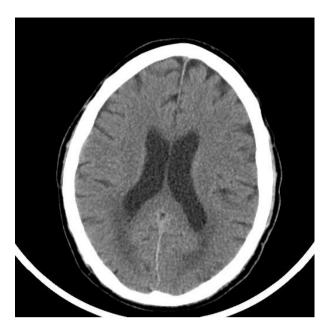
Subsequent CT scan showing symmetric, hypodense periventricular lesions.
